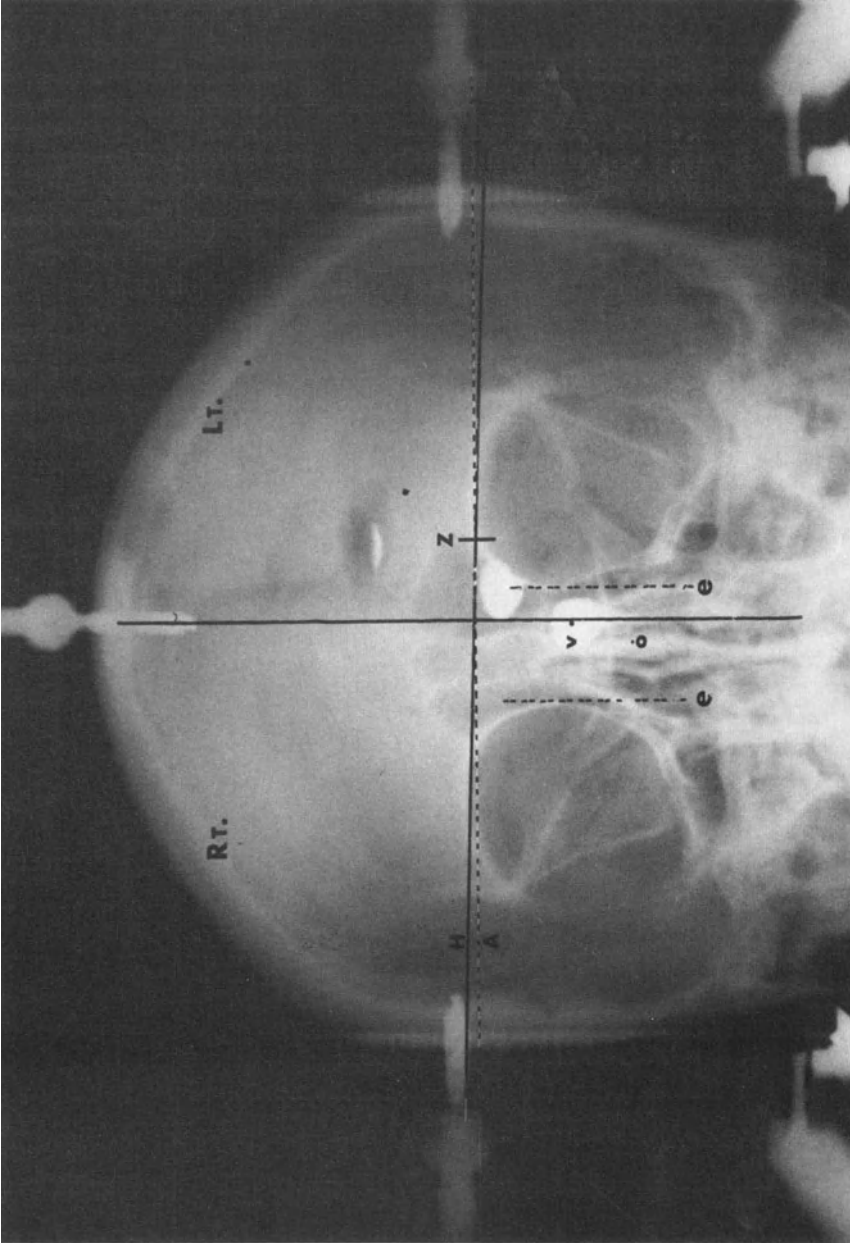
Anterior-posterior roentgenogram with central roentgen ray beam aligned in mid-vertical plane of frame. Z is in the target position for a left thalamotomy. The line H is the horizontal plane of the brain drawn parallel to the orbital roofs. Line A is the horizontal plane of the stereotactic frame intersecting H at the mid-vertical plane. The angle formed by the intersection of lines A and H is the *tilt* angle. V represents the center of the third ventricle. Dotted parallel lines (e) are tangent to the medial orbital walls. Point O is equidistant between lines e. The horizontal distance between O and V represents the displacement due to *rotational* angulation. There is no collateral (mediolateral) misalignment, because point V coincides with the mid-ventricular plane of the Leksell stereotactic frame.
